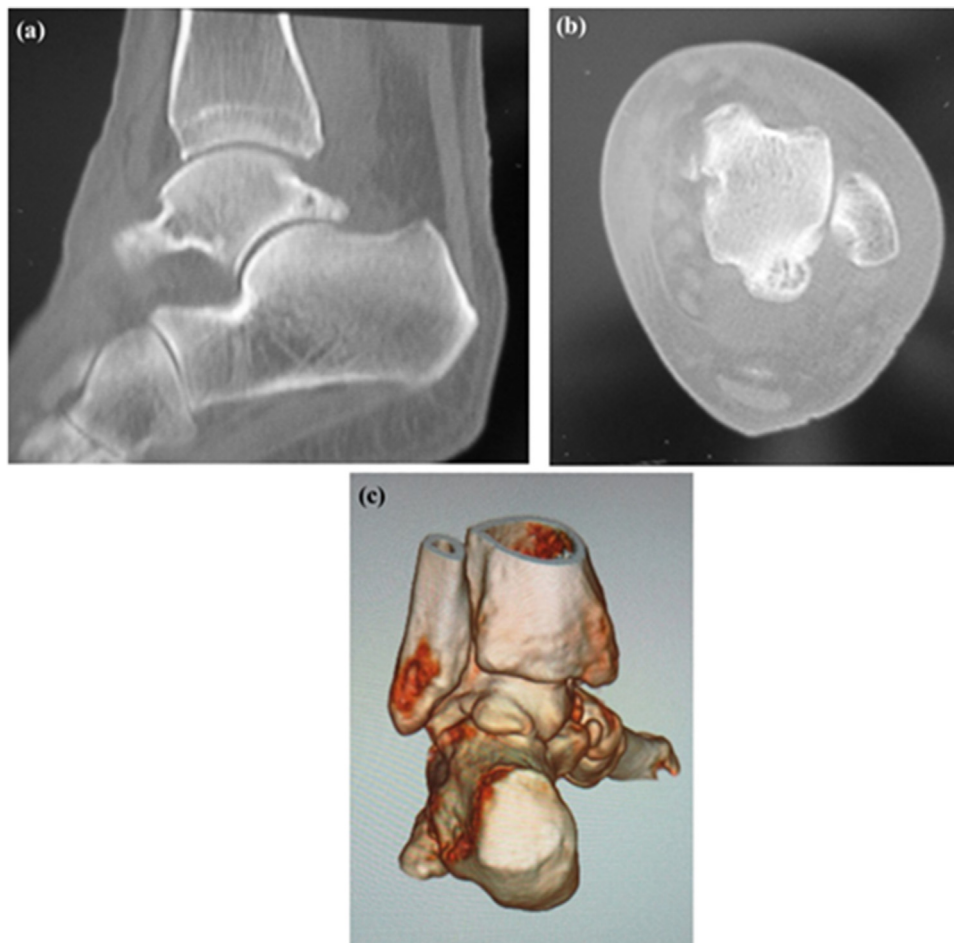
Computed tomography scans showing an enlarged posterior talar process in the posterior ankle (a) on plain sagittal, (b) axial, and (c) three-dimensional views.
